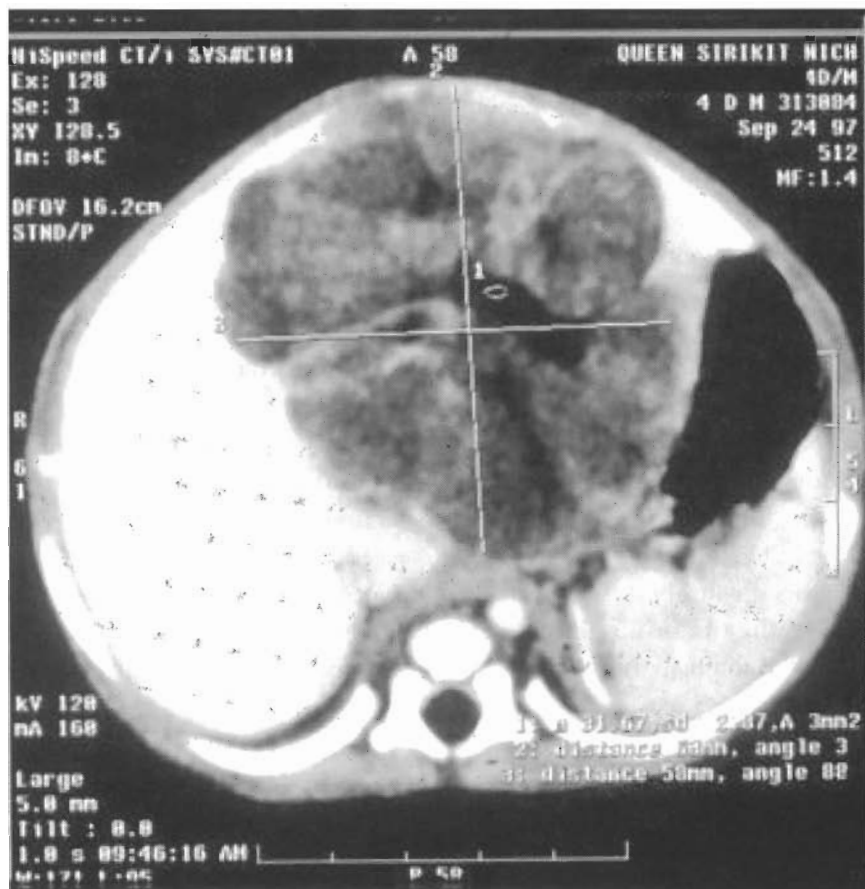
CT image shows tumor occupying the left lobe of liver.
